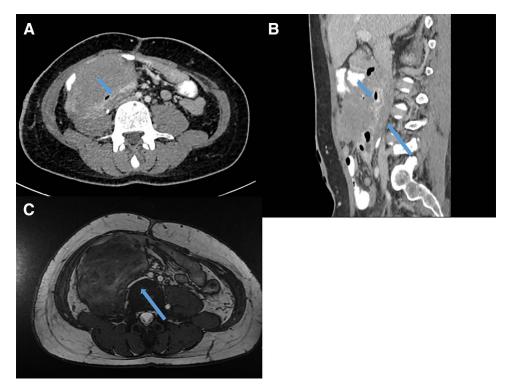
Desmoid tumor encroachment on critical structures. Axial (A) and sagittal CT (B) images as well as axial T2-weighted MRI image (C) demonstrating a desmoid mass encasing duodenum (short arrow) and abutting cava (long arrow).
